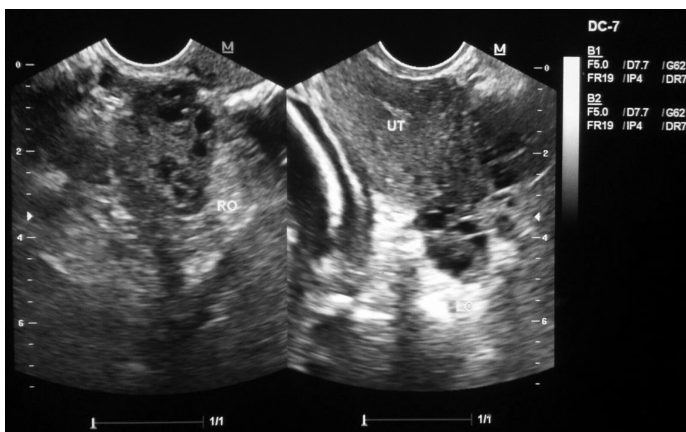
Transvaginal Ultrasound showing bilateral ovaries to rule out ovarian pregnancy.
